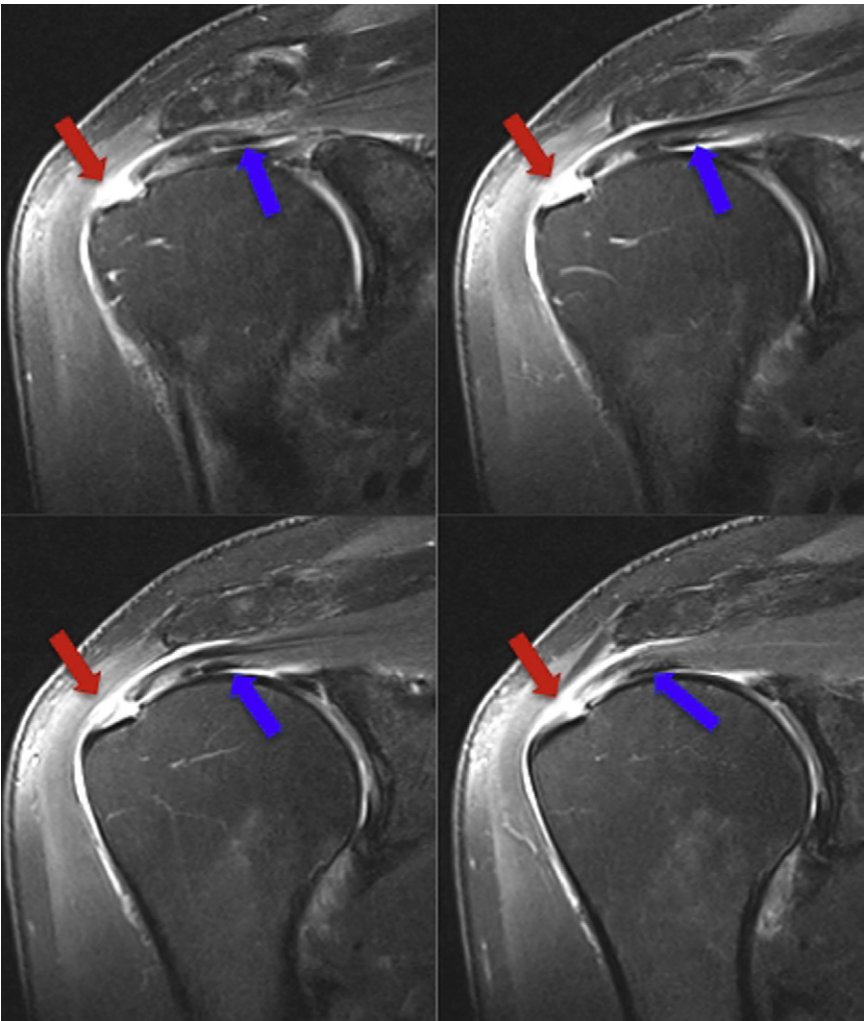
Crescent-shaped tear, coronal oblique plane. Multiple consecutive coronal oblique fat-suppressed T2-weighted images of the right shoulder from the same patient as in Figs. 12 and 13 demonstrate a crescent-shaped full-thickness tear at the junction of the supraspinatus and infraspinatus tendons (*red arrows*). The rotator cable courses along the undersurface of the supraspinatus and infraspinatus tendons (*blue arrows*).
